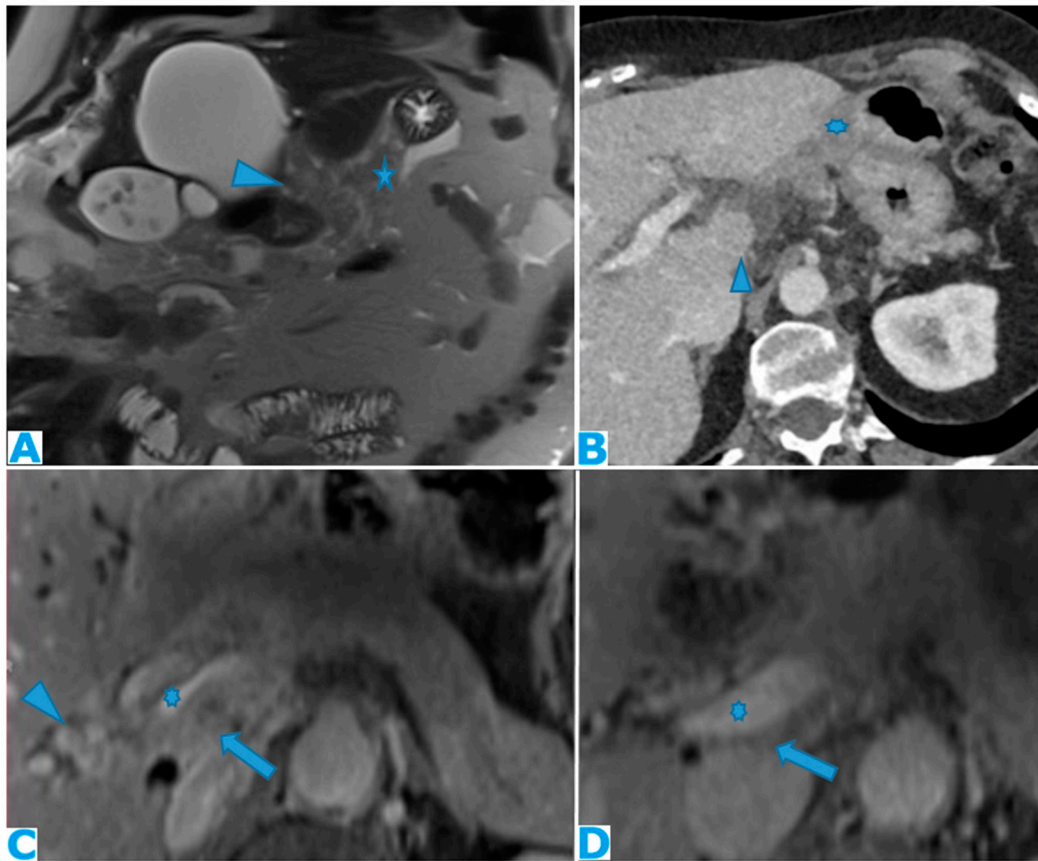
Axial CE-CT (A). PC from ovarian carcinoma: deposits within the gastrohepatic (*) and the hepatoduodenal ligaments (arrowheads). Coronal T2WI (B). PC from ovarian carcinoma: deposits within the lesser omentum: Identify its two components, the gastrohepatic (*) and the hepatoduodenal (arrowhead) ligaments. Axial CE portal phase FST1W1 (C-D), the current study (C) and from one year prior (D), for comparison. PC from colon adenocarcinoma: Deposits within the gastrohepatic ligament (lesser omentum) (arrows). Note the compression of the portal vein (*) on C and the development of collateral vessels (arrowheads).
